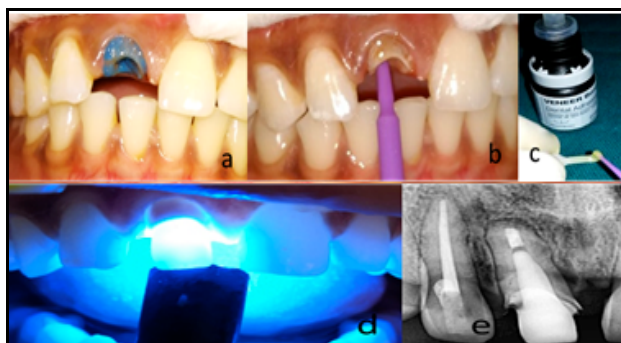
a) Etchant application, b) Bonding agent applied, c) Application of direct veneer bonding on post, d) Curing, e) Post cementation radiograph
